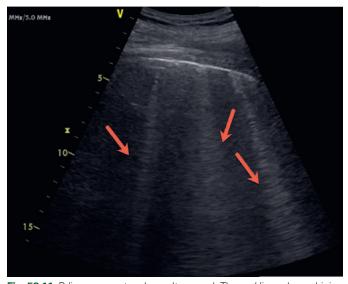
B-lines present on lung ultrasound. The *red lines* show shining beam–like artifacts when there is interstitial pulmonary edema.
